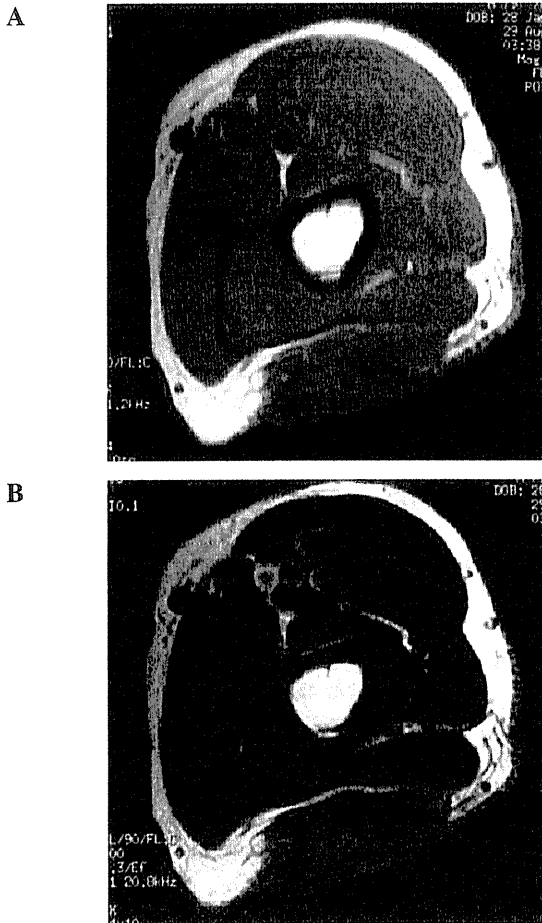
MRI showed a soft-tissue mass above the fascia of the triceps with (A) a low signal intensity on T1-weighted images and (B) a heterogeneous signal intensity on T2-weighted images.
